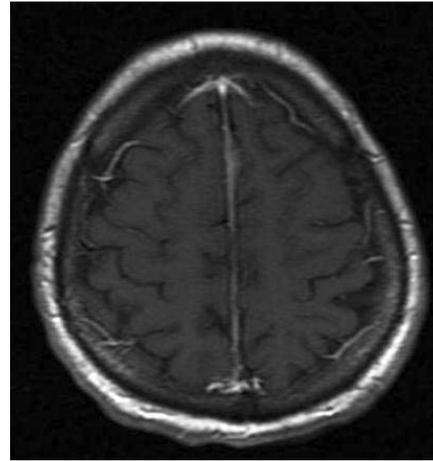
Axial Gd-enhanced T1-weighted magnetic resonance image showing decreased tumor mass in the inter-hemispheric region after 8 cycles of chemotherapy.
